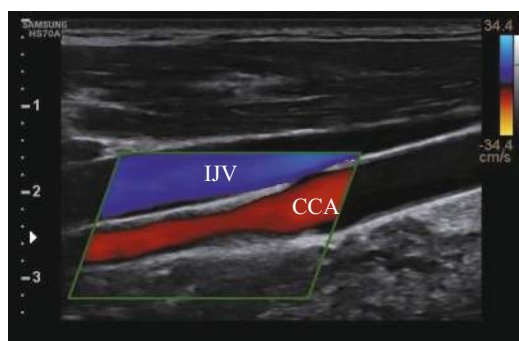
Longitudinal view of neck vessels with Doppler-US. IJV, internal jugular vein; CCA, common carotid artery
